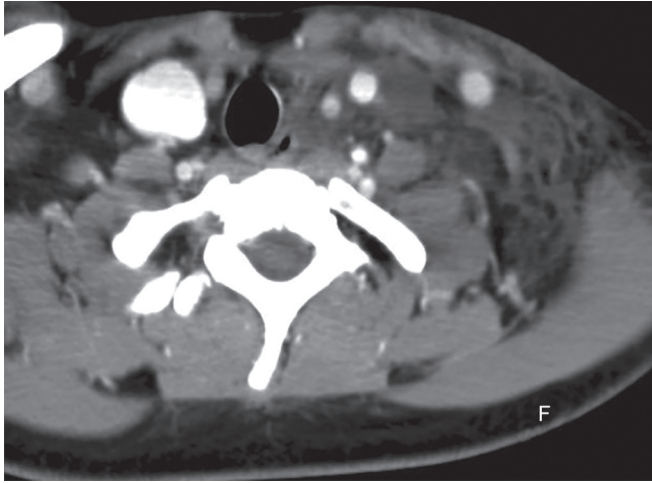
Both CT scan showed swelling at the insertion of the thoracic duct
